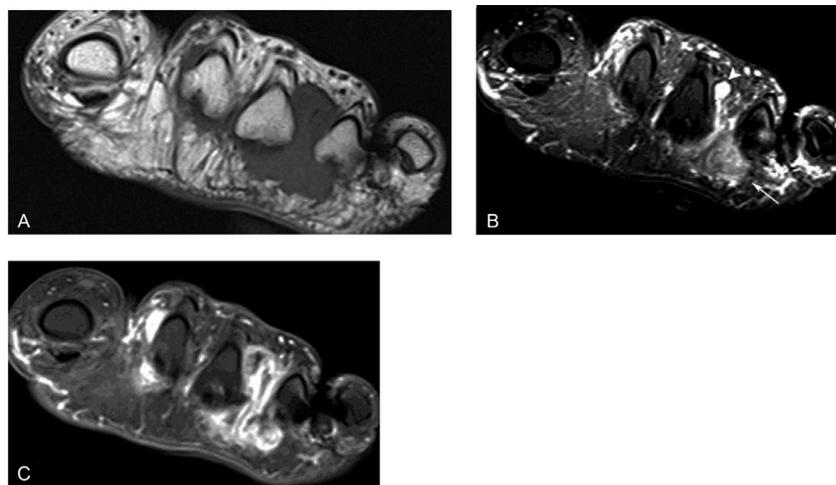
Rheumatoid nodule. (A) Coronal short-axis T1WI shows a lobulated mass between the third and fourth metatarsal heads. The lesion is iso in signal to the muscle. (B) On coronal short-axis fat saturated T2WI, the lesion is hypointense (white arrow). A small amount of fluid is seen in the intermetatarsal bursa (arrowhead). (C) Coronal short-axis fat saturated postcontrast T1WI shows intense heterogeneous enhancement. T1WI, T1-weighted images; T2WI, T2-weighted images.
